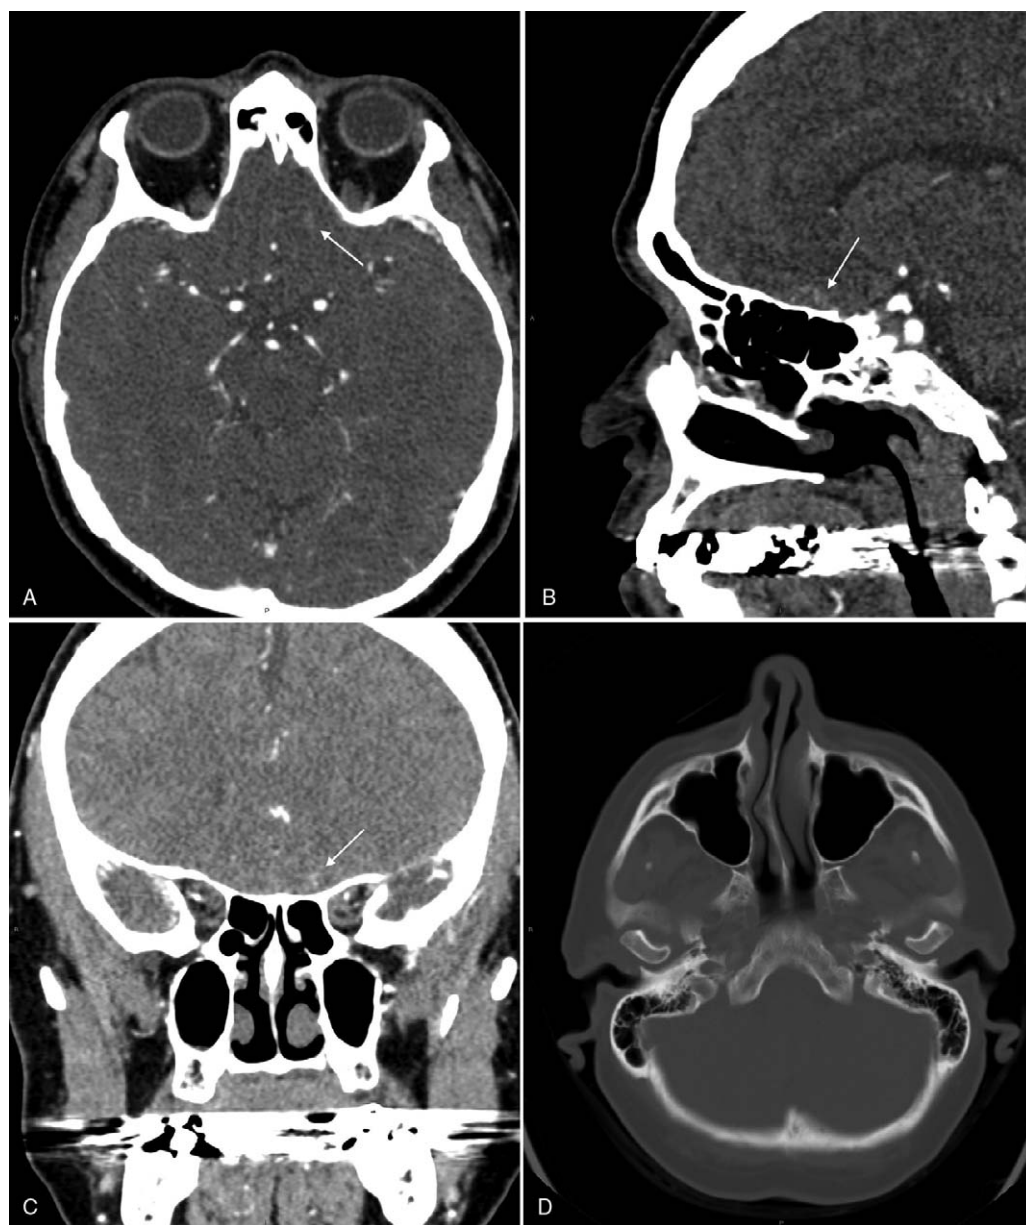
A–D, CTA in 57-year-old woman with smoke smelling phantosmia (A, axial, B, sagittal, C, coronal) and axial bone window CT (D). CTA postcontrast demonstrates faint enhancement left olfactory tract (white arrow). Axial bone window CT (D) rightward nasal septal deviation and right osseous spur, paranasal sinuses were clear without fluid levels, retention cysts, or polyps.
